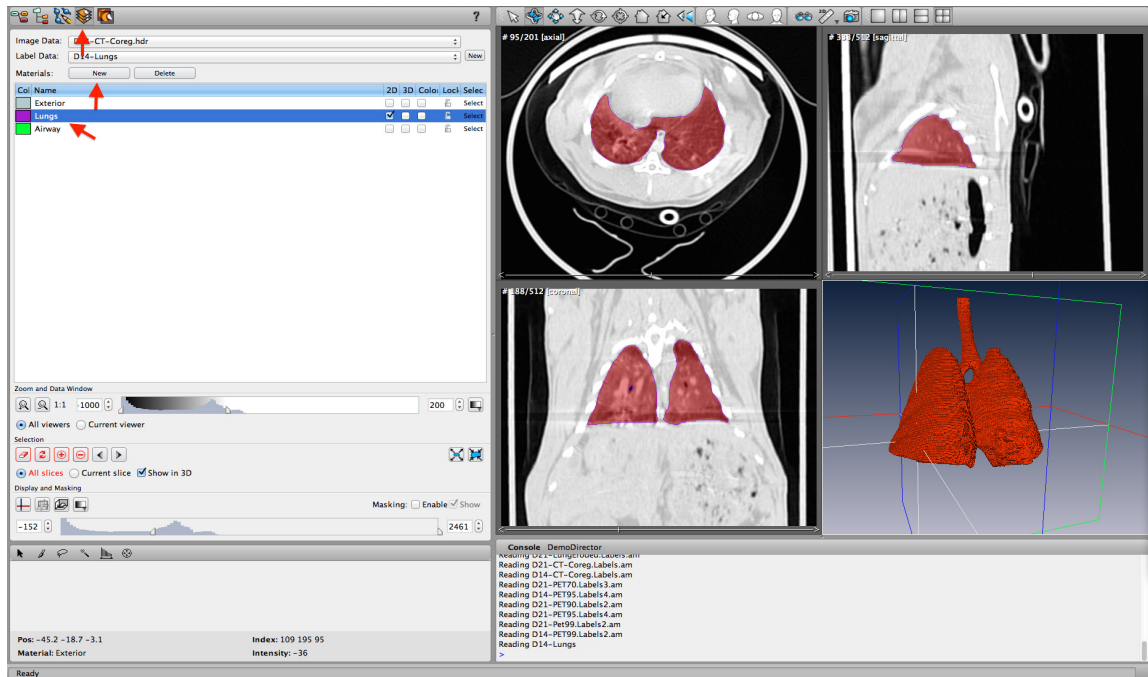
Amira CT segmentation
